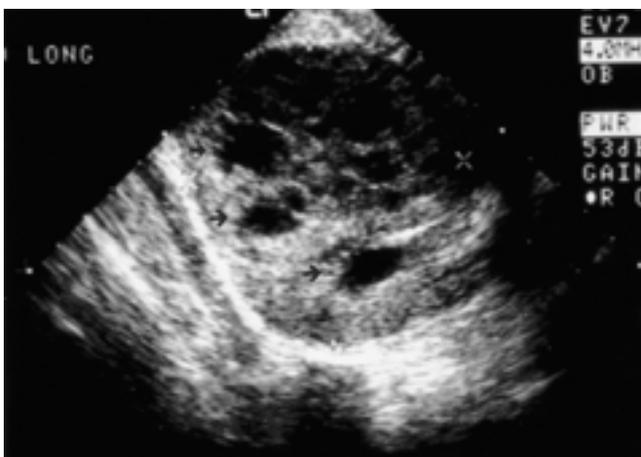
Ultrasonography shows a 10.3×8 cm sized, mixed echogenic mass with a multiple focal hypoechoic area (arrows).
